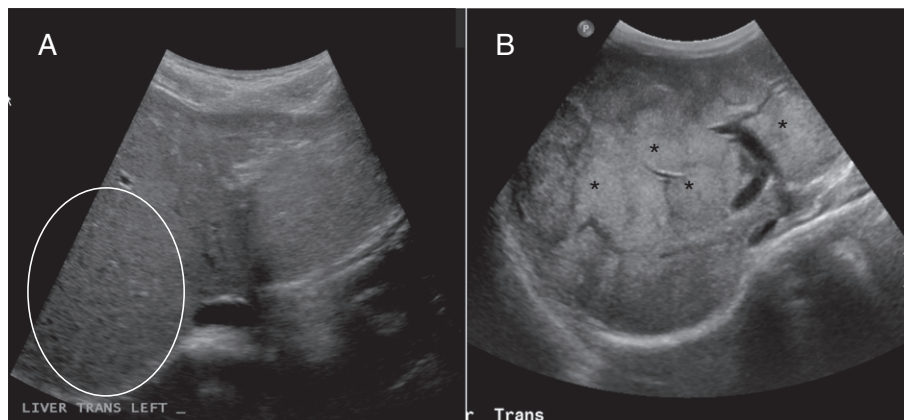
Gray-scale ultrasound imaging of varying forms of CF cirrhosis. A-A focal area of micronodularity (circled) in the liver of a CF patient with focal biliary cirrhosis. B-Multiple and large nodules (asterisks) throughout the liver of a CF patient with multilobular cirrhosis. Images courtesy of Dr. Roger Harned.
